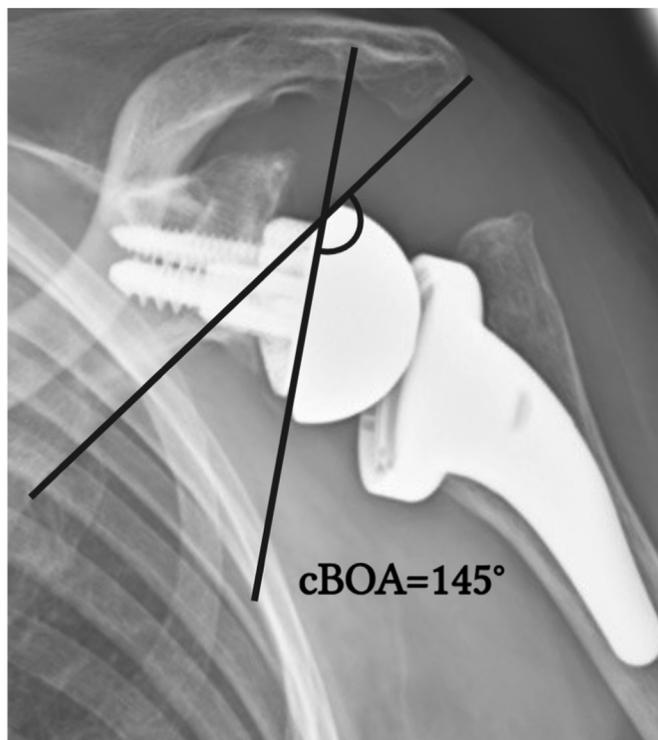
Postoperative anteroposterior left shoulder radiograph of a female patient with cuff tear arthropathy and central glenoid erosion managed with short stem reverse shoulder arthroplasty with a superior augmented metallic base plate. The base plate orientation angle value is 4° higher than the normal values ($136^\circ \pm 5^\circ$), indicating a slight inferior tilt of the base plate. cBOA, corrected base plate orientation angle.
